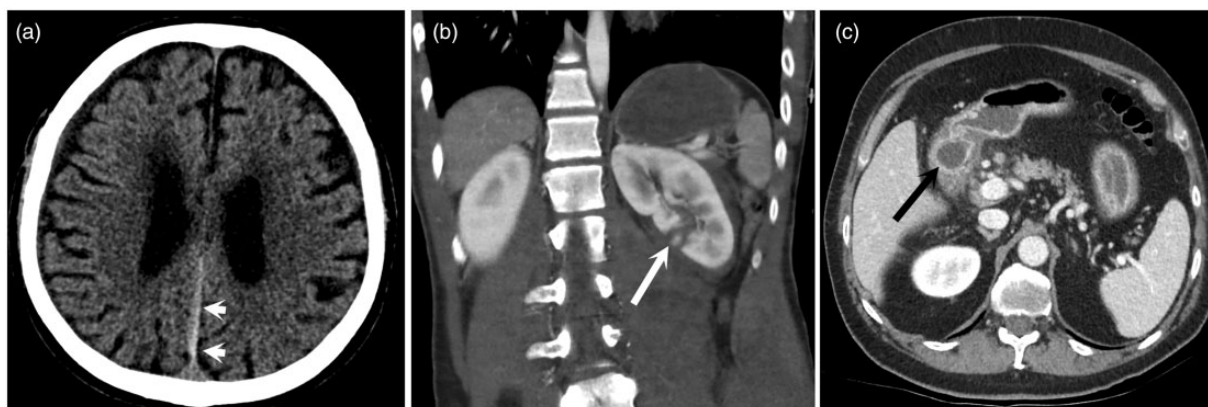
Example case of missed CT diagnoses. (a) An axial CT image showing a small subdural effusion (white arrowheads) adjacent to the falx. (b) A coronal CT image describing a laceration (white arrow) of the left kidney. (c) An axial CT image depicting a large gallstone (black arrow) perforating to the lumen of the duodenum.
